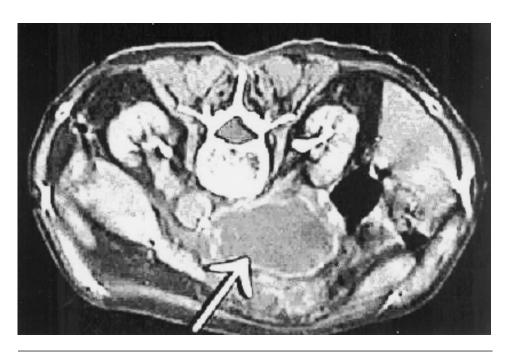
CT scan appearance of a pancreatic pseudocyst. The head of the pancreas is enlarged with the presence of a pseudocyst in the center. This is a complication of acute pancreatitis.
